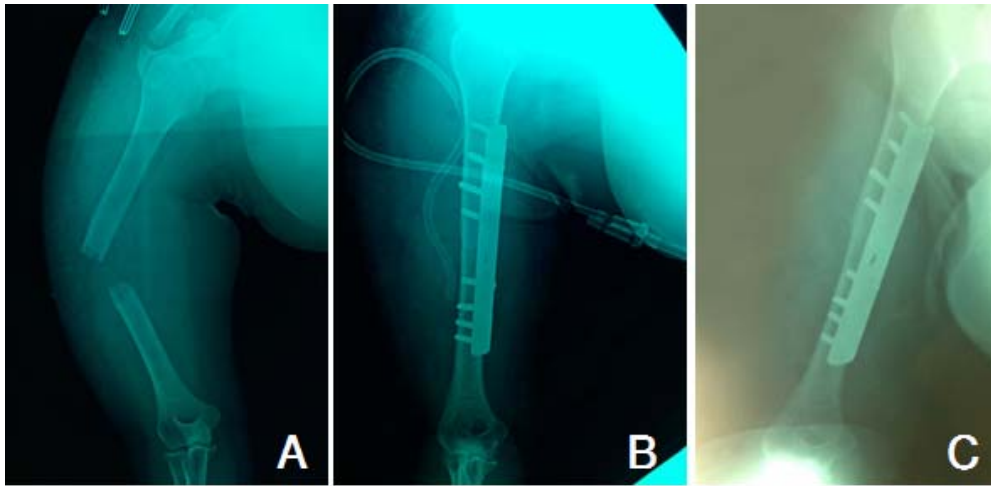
(A) Pre-operative X-ray, (B) Immediate post-operative X-ray, (C) Follow-up X-ray after 6 weeks.
